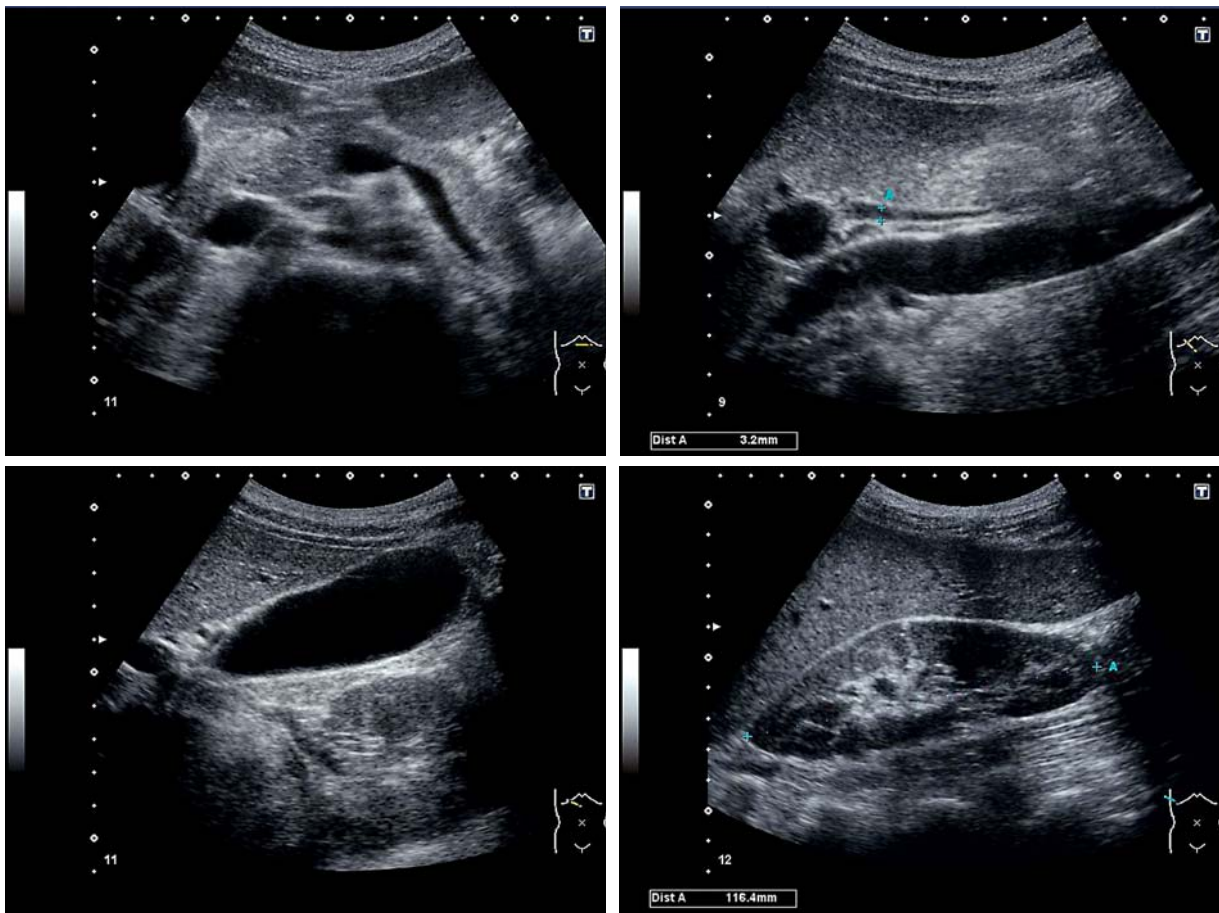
Ultrasound of the upper abdomen. Images show the usual suspects for RUQ pathology: pancreas, distal common bile duct, gall bladder and right kidney
